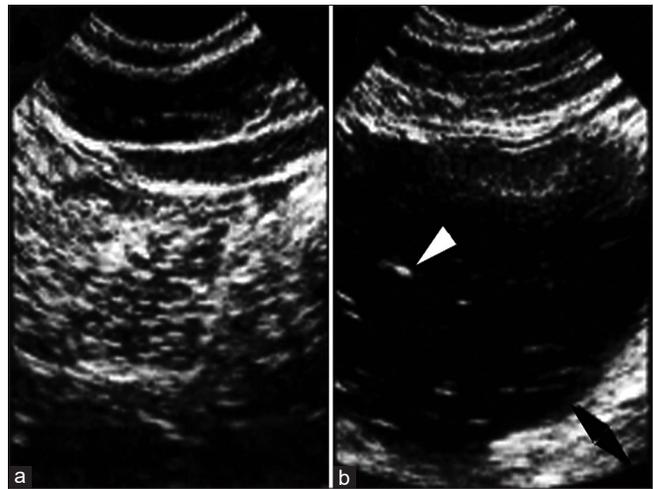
(a and b) Sample sonograms of the duodenum without (a) and with (b) water contrast
